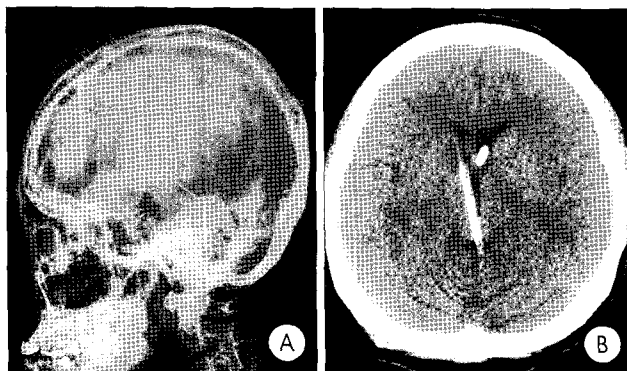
Lateral skull x-ray(A) and computed tomography scans(B) show the catheter passing through the lateral ventricle, third ventricle, and cerebral aqueduct and devices of lateral ventriculo-peritoneal shunt.
